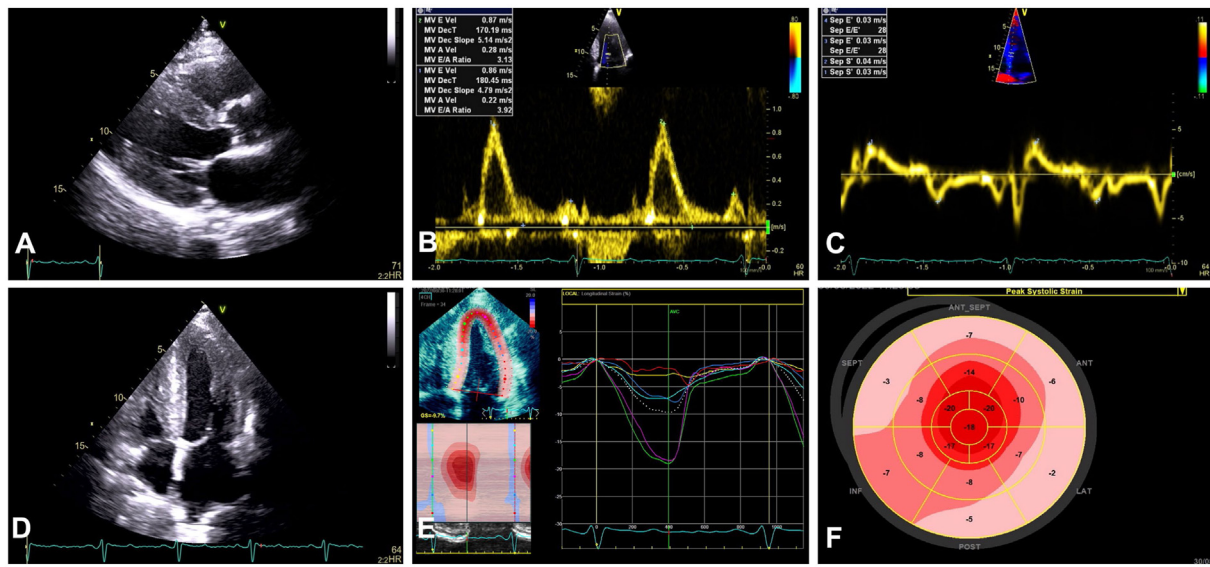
Typical echocardiographic features of CA. A. Parasternal long axis view demonstrating increased LV wall thickness. B. Transmitral flow showing restrictive filling (Grade 3 diastolic dysfunction). C. Reduced mitral annular e' velocity. D. Apical 4 chamber view with myocardial speckling, increased thickness of the RV free wall and enlarged atria. E. Apical 4 chamber global longitudinal strain which is reduced. F. Typical “cherry-on-top” segmental strain pattern.
